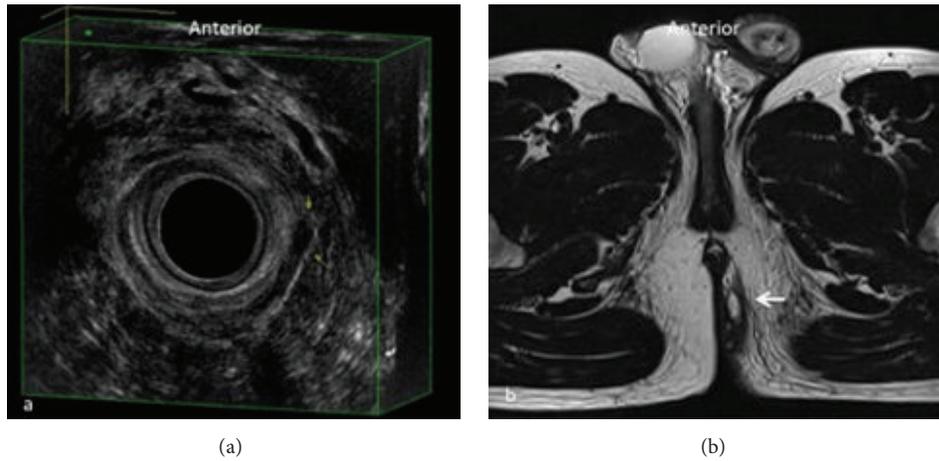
Submucosal fistula in the superficial plane corresponding to the level of the distal extremity of anal canal. In (a) 3D-EAUS, including the hyperechoic layer of the submucosal portion of the external anal sphincter (EAS), shows a submucosal fistula extending from 3 o'clock to 5 o'clock, lying external to the submucosal portion of the EAS (yellow arrows). The same plane on MRI (b), which could be avoided in this kind of fistulas (white arrow); 3D-EAUS is often sufficient as a preoperative diagnostic method.
